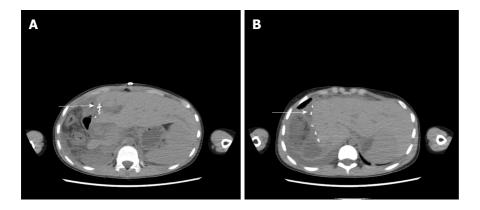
Review of abdominal computed tomography. A: The high-density shadow indicated by the white arrow represents metal titanic clips; B: Hyperplasia of the residual liver was good, and there was no recurrence of echinococcosis.
